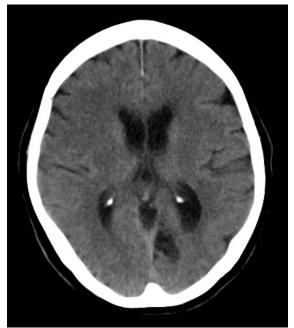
Urgent plain CT brain of the patient
